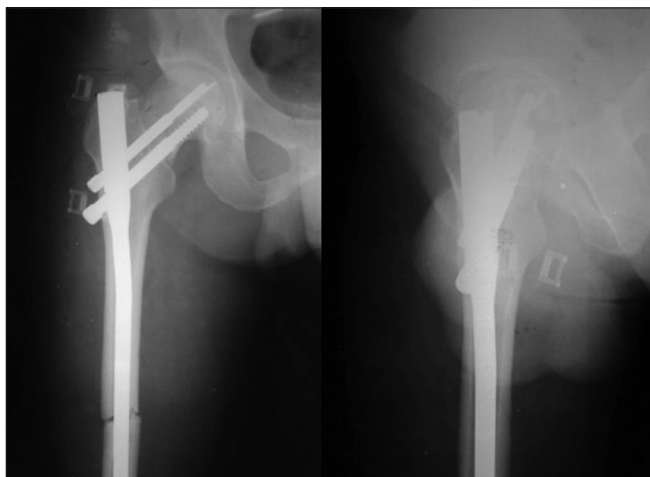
Postoperative radiographs (anteroposterior and lateral view) showing the long proximal femoral nail and the broken guidewire near the lower margin of the proximal-most screw
